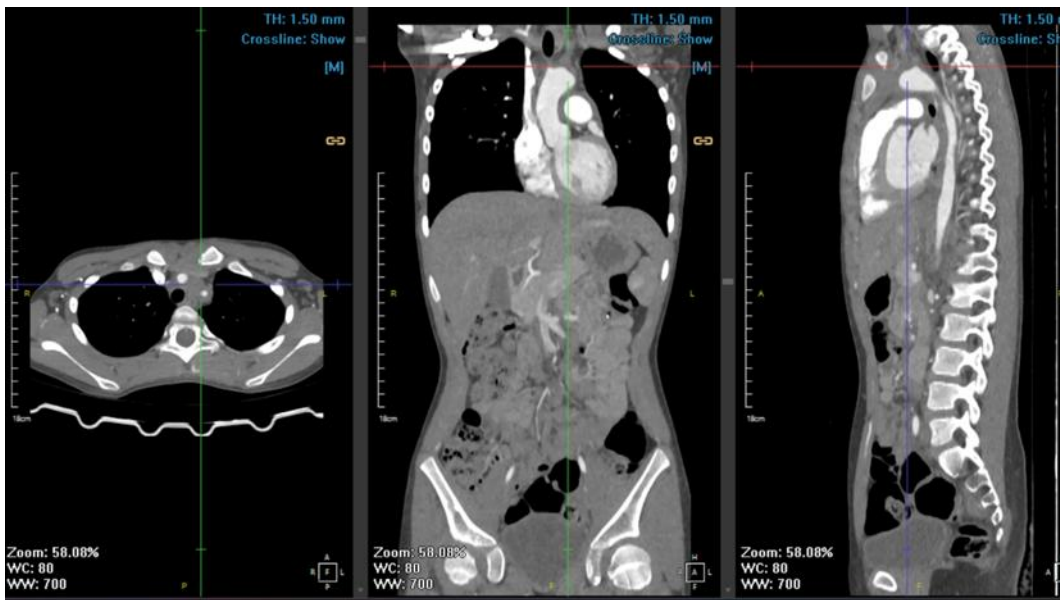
CT-scan Angiography Examination
